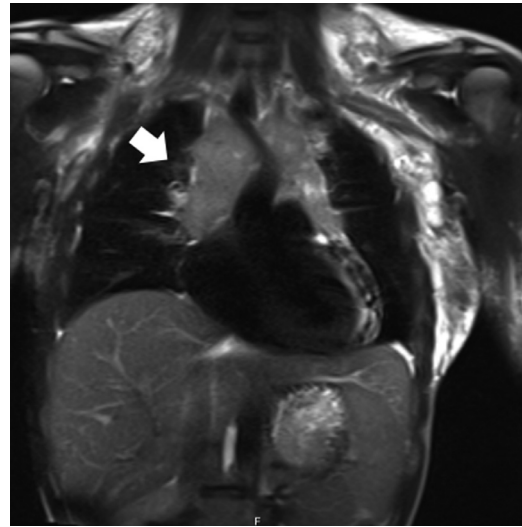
A gross mediastinal mass fully embedding the SVC (coronal T2 MRI).
